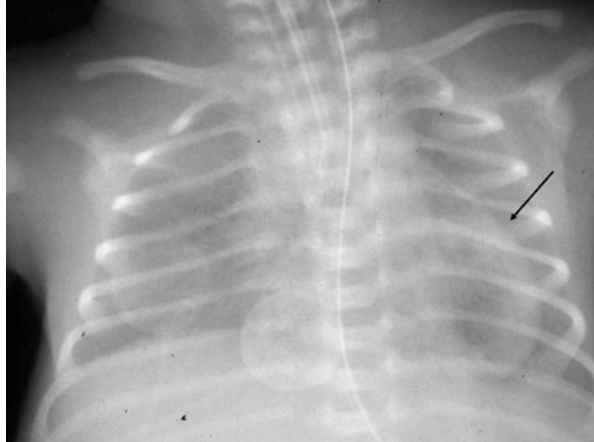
Radiograph depicting pneumopericardium in an infant receiving positive pressure ventilation. The radiolucent area surrounding the heart is created by air in the pericardium
